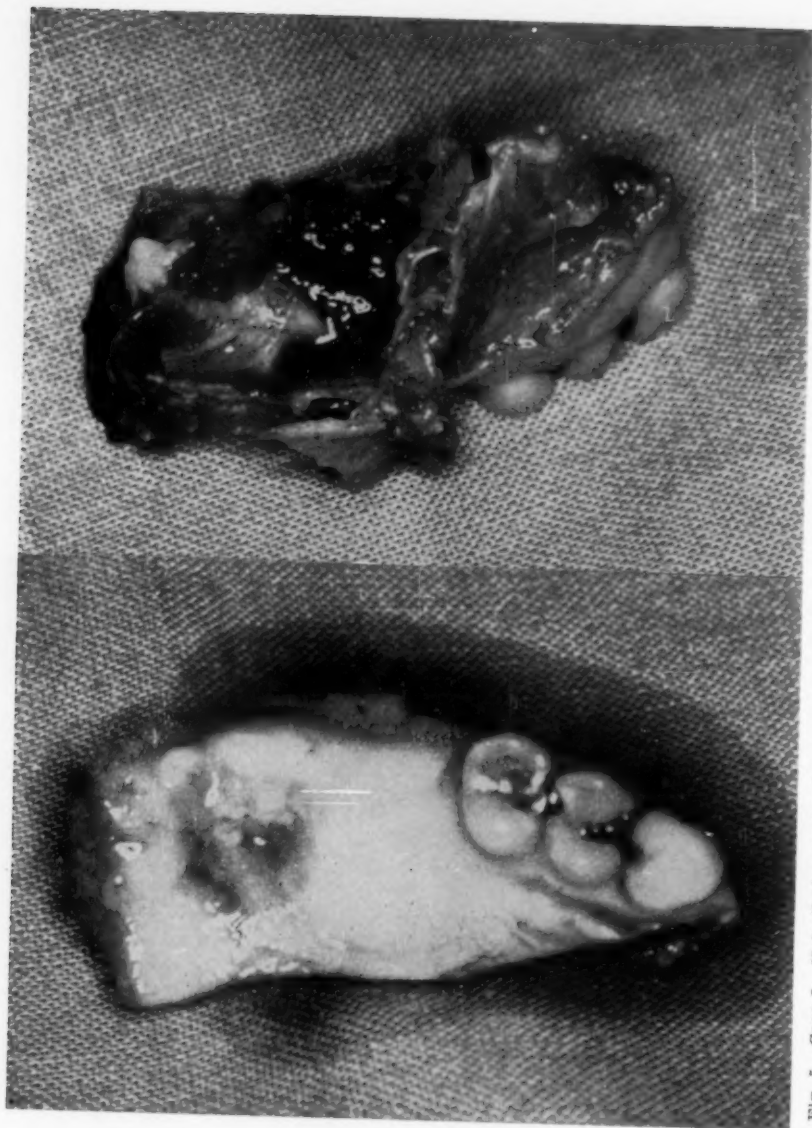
Case 5. Note that some healing has occurred in the biopsy site. The thickened antral mucosa, considered tumor extension from the X-ray appearance, proved to be inflammatory.
